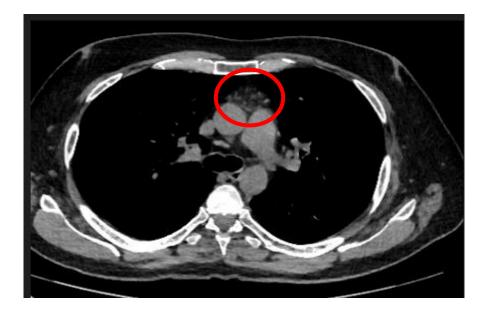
Thymus CT in COVID-19. Axial mediastinal window CT showed nodular pattern (infiltration) of the thymus. Abbreviations: COVID-19 coronavirus disease 19, CT computed tomography.
